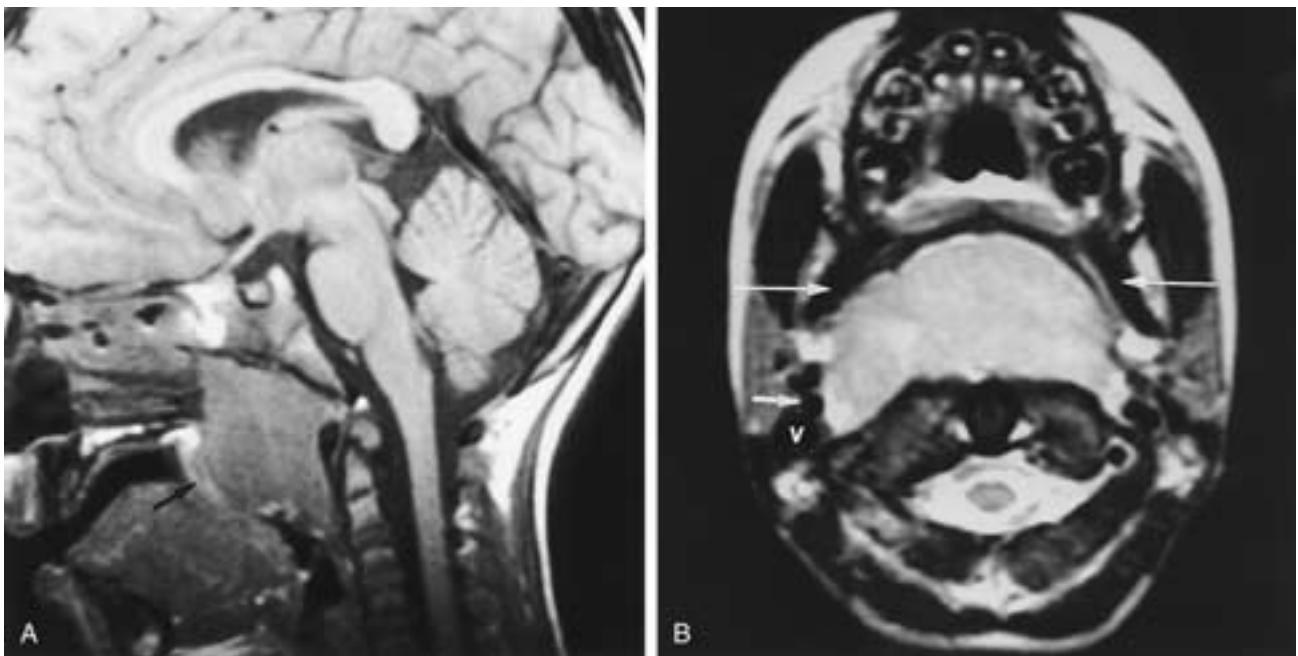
NHL in a 6-year-old boy with severe airway obstruction. A, T1-weighted sagittal image shows a large nasooropharyngeal mass obliterating the airway. The soft palate (arrow) is pushed anteroinferiorly by the mass. B, On this FSE T2-weighted axial image, the mass has pushed the vessels (arrow, internal carotid artery; v, internal jugular vein) and the pterygoid muscles (long arrow) laterally. Despite the large size, there is no skull base destruction and no cervical adenopathy.
